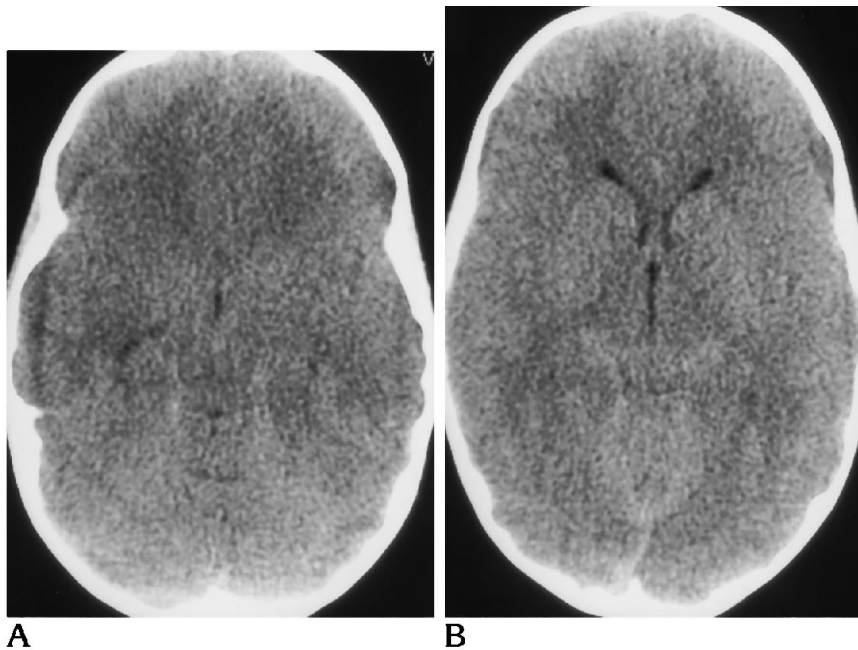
A, Noncontrast CT at the level of the temporal horns showing effacement of perimesencephalic cisterns.
